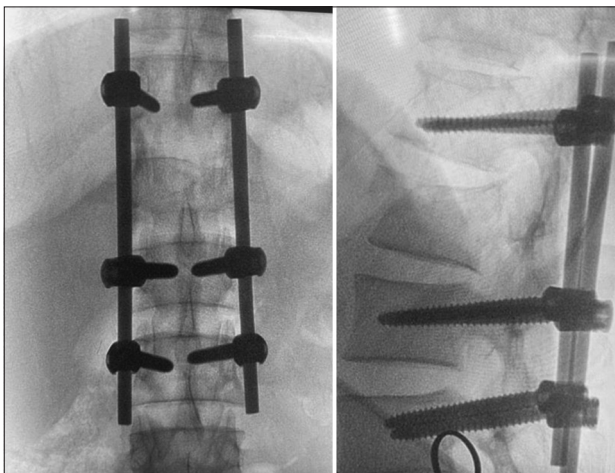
Sagittal X-ray anteroposterior/lateral view showing transpedicular fixation at L2, L4, L5 level
